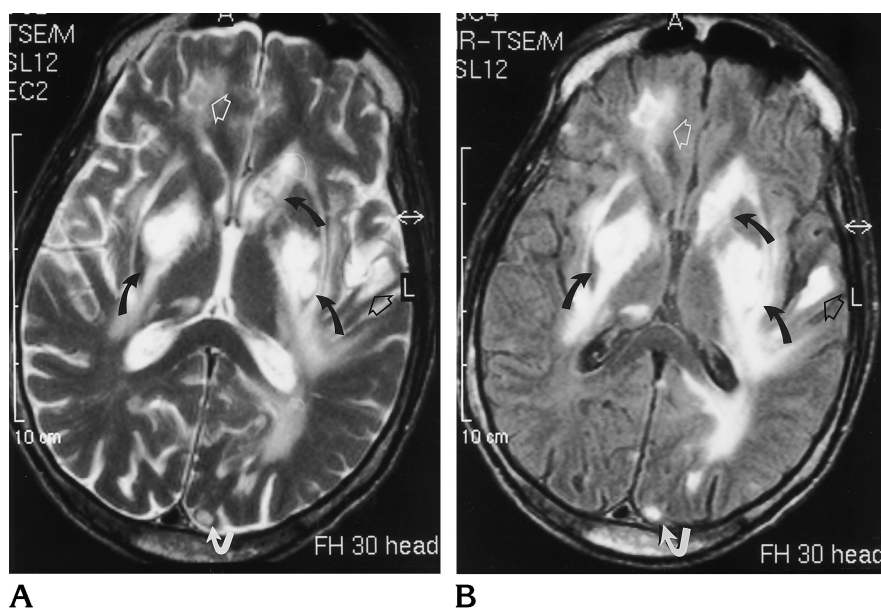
Autopsy-proved cerebral toxoplasmosis in an AIDS patient. Multiple hyperintense lesions in both basal ganglia regions (solid black arrows) are well demarcated on both T2-weighted fast spin-echo (3752/120/4) (A) and FLAIR fast spin-echo (7000/150/4; inversion time, 2100) (B) MR images. Note additional lesion in the white matter of the right frontal lobe (open white arrow), which also is clearly visible with both techniques. Small lesions located in the cortical regions of the right frontal and left occipital lobe (curved white arrow), as well as the lesion in the left superior temporal gyrus (open black arrow), can be seen to better advantage on the FLAIR image.
